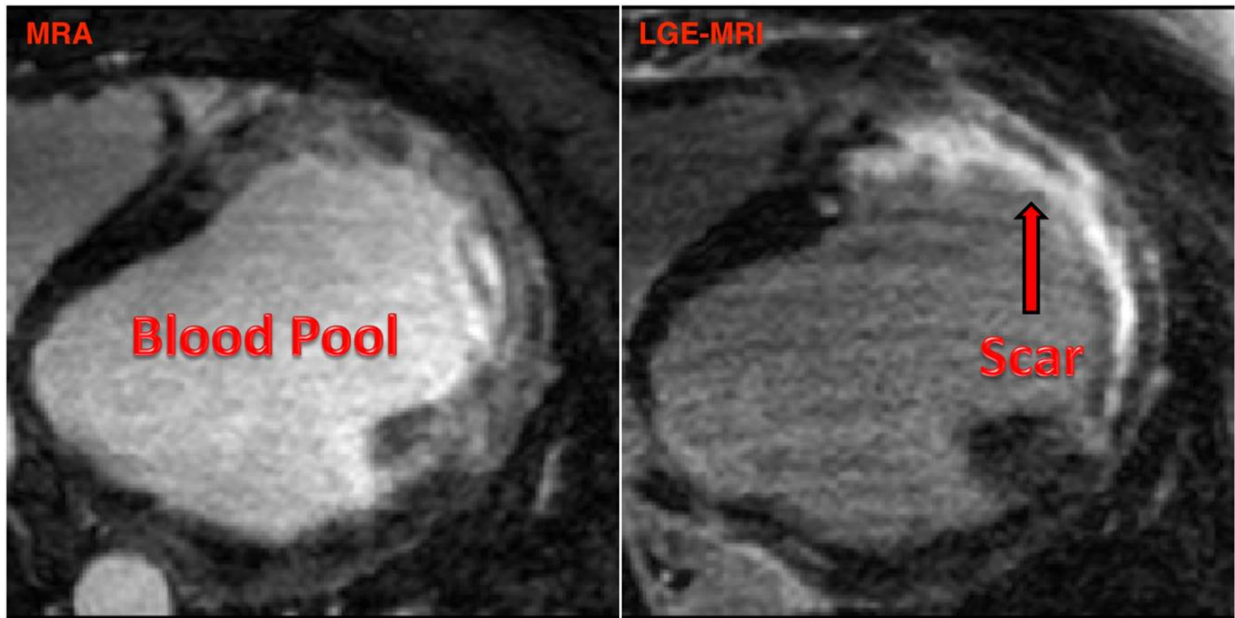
Short-axis view of left-ventricular using an MRA image (left) and an LGE-MR image (right).
